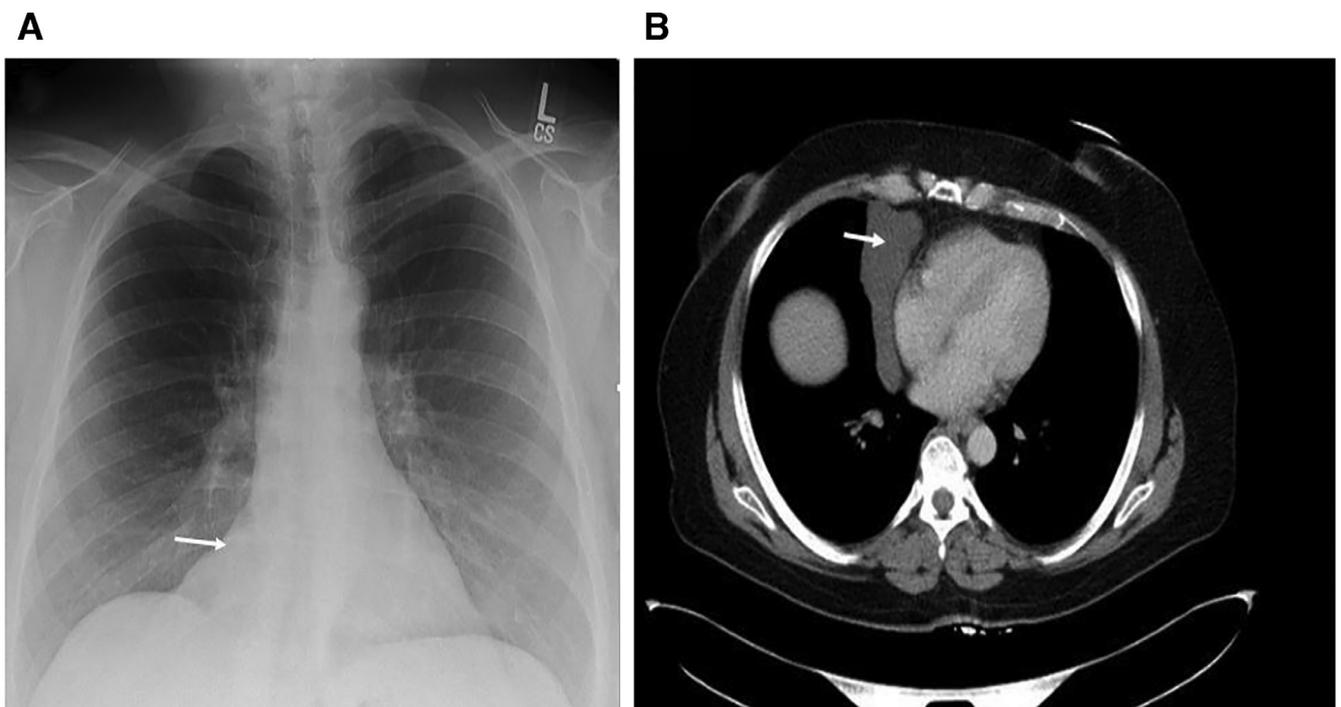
(A) Chest radiograph showing a triangular density (white arrow) at the right cardiophrenic angle (B) CT chest with contrast showing a thin-walled, nonenhancing pericardial mass (white arrow) compatible with a pericardial cyst. CT = Chest tomography.
